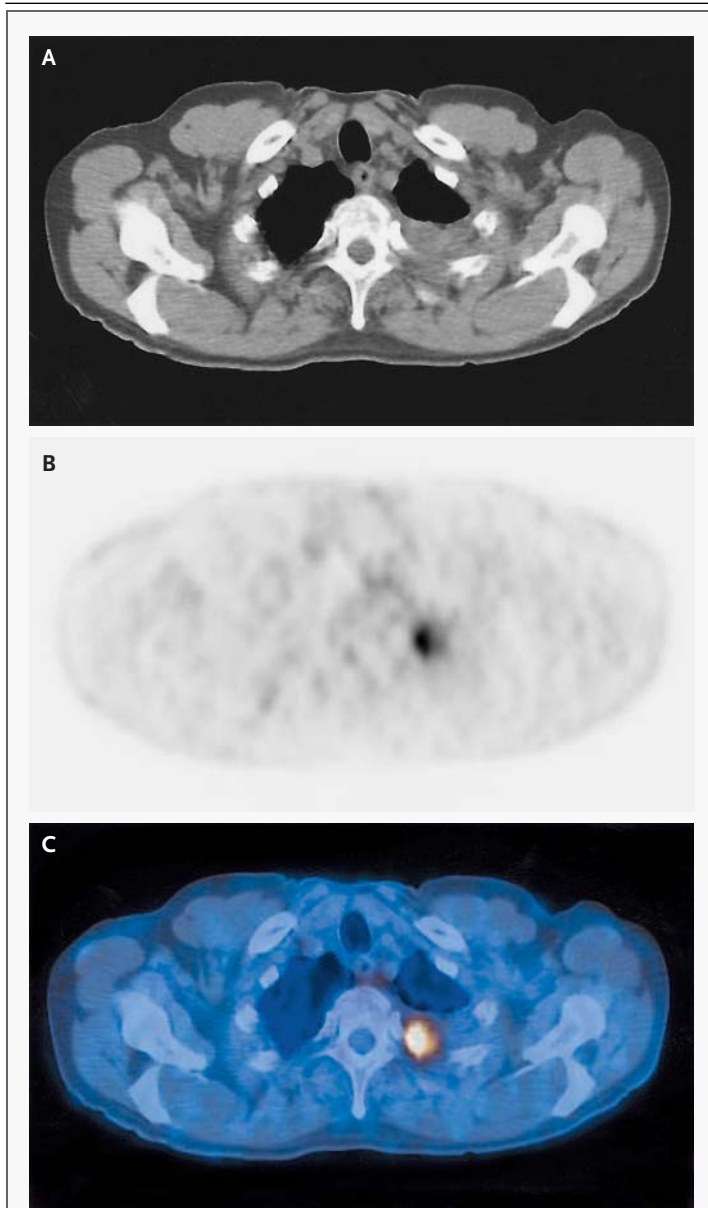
CT Scan, Attenuation-Corrected PET Scan, and Coregistered PET–CT Scan of a Patient with Non–Small-Cell Lung Cancer.
